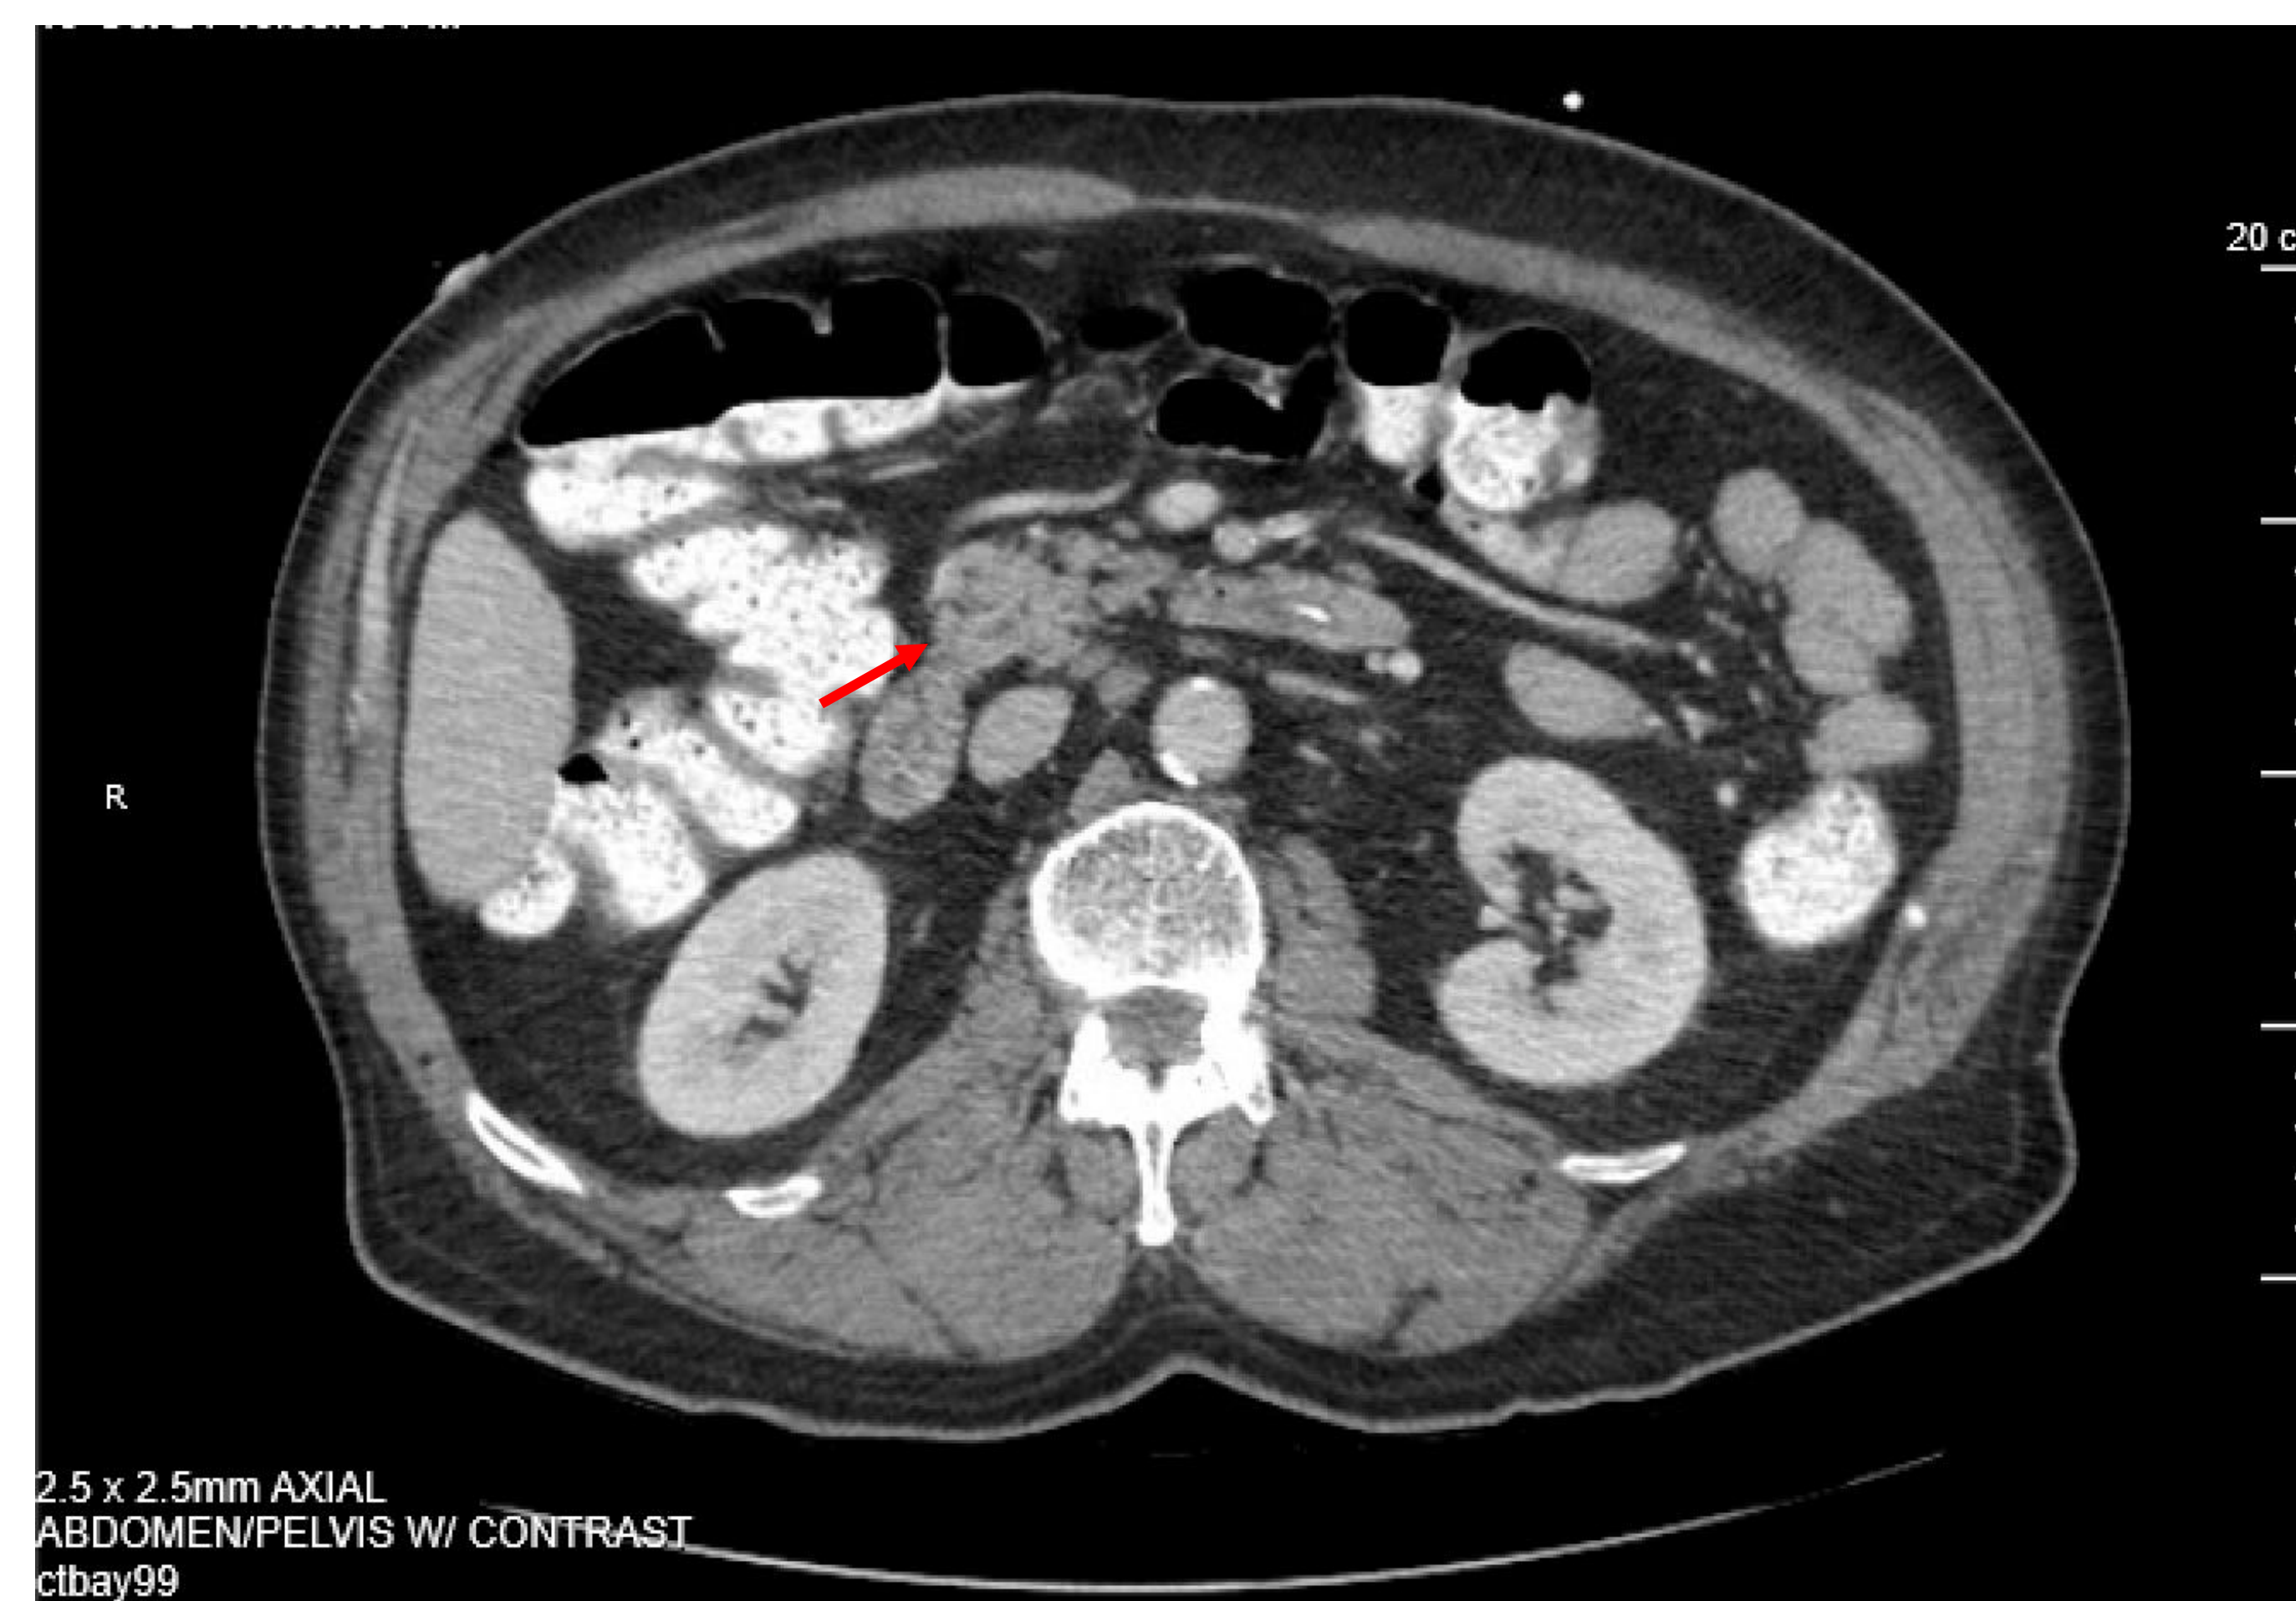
Axial view of CT abdomen/pelvis w/ contrast.
